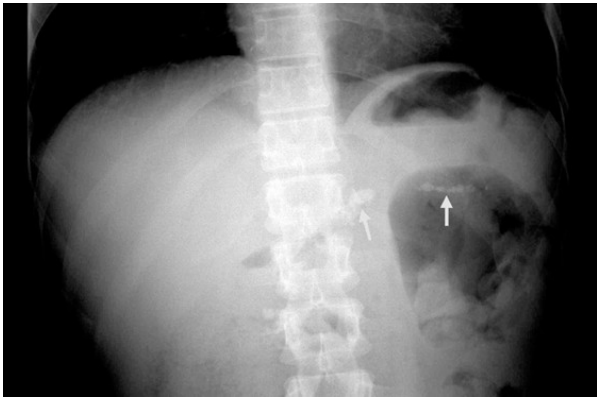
An X-ray of the abdomen showing calcifications in the pancreas.
